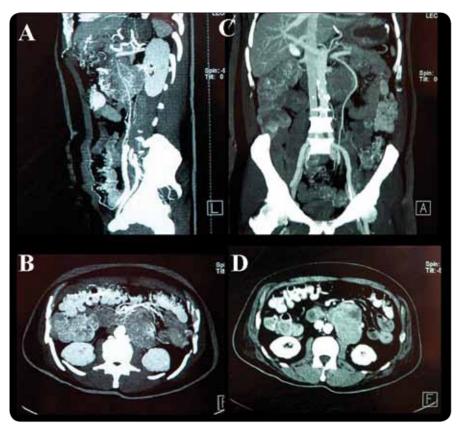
The abdominal CT scan demonstrated a well demarcated tumor measuring 6 x 5.5 cm at the third part of the duodenum compressing and abutting forward the duodenum.
